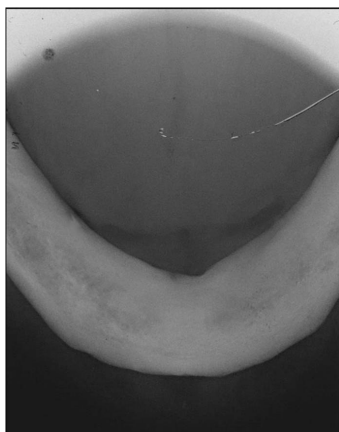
Occlusal radiograph of the mandible during 7-day postoperative control
